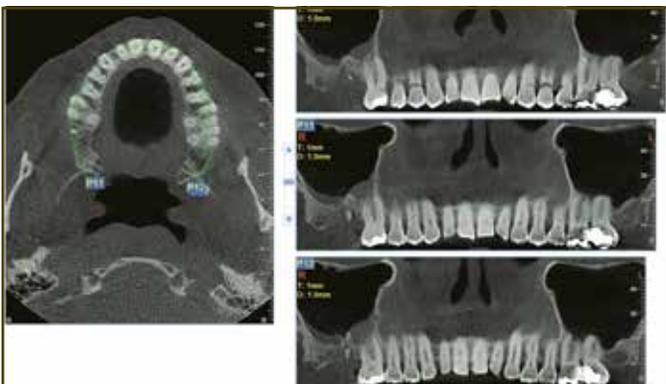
oroantral fistula, retained root tip, and apical pathology defined using CBCT 3D imaging.
